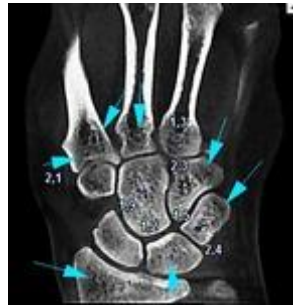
CBCT-image of the left wrist with the detailed mapping of the bone structure...
